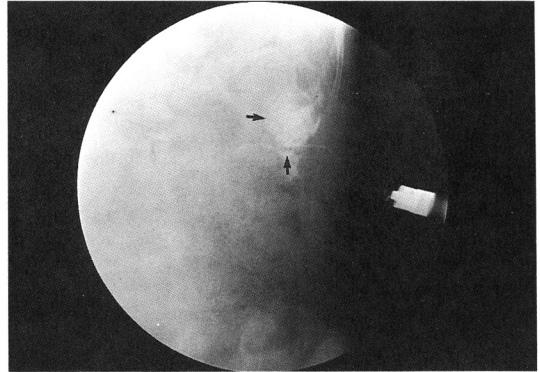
Aspiration and drainage of intrasplenic abscess under ultrasound guidance.
